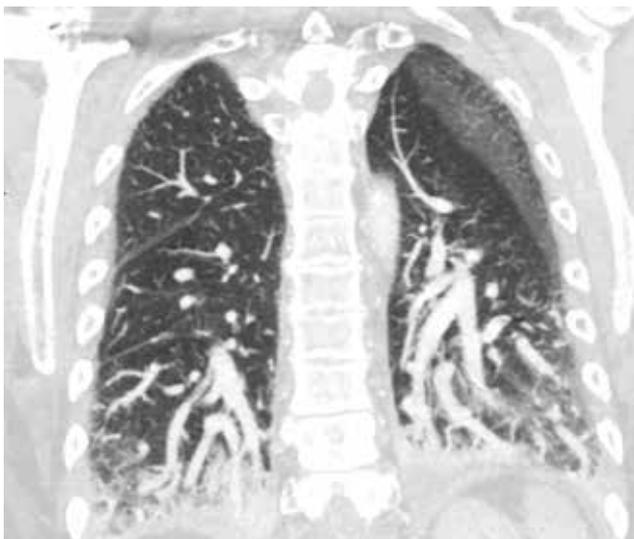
CT pulmonary angiogram of our patient
